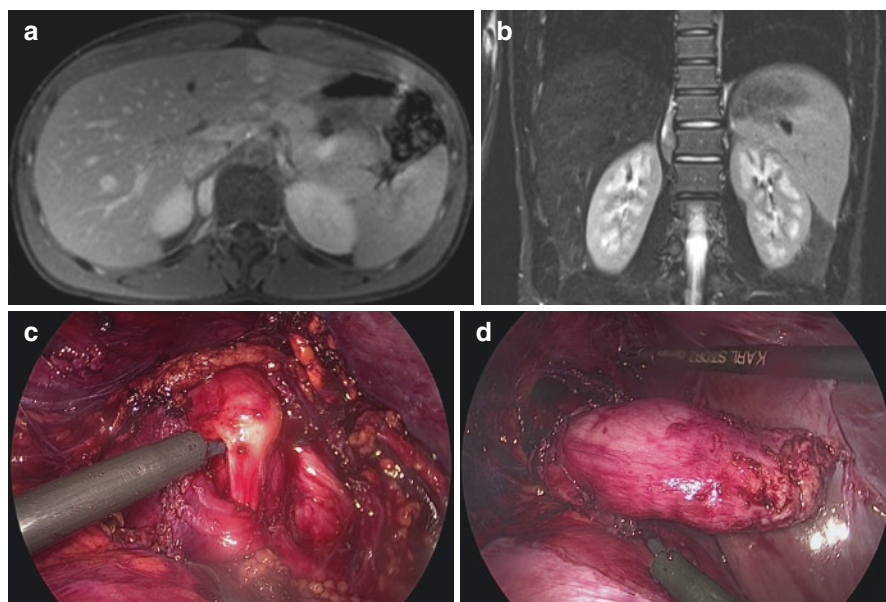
Paravertebral right-sided abdominal neuroblastoma in a child with Opsomyoclonus Syndrome. (a, b) Preoperative MRI Scan. (c)
